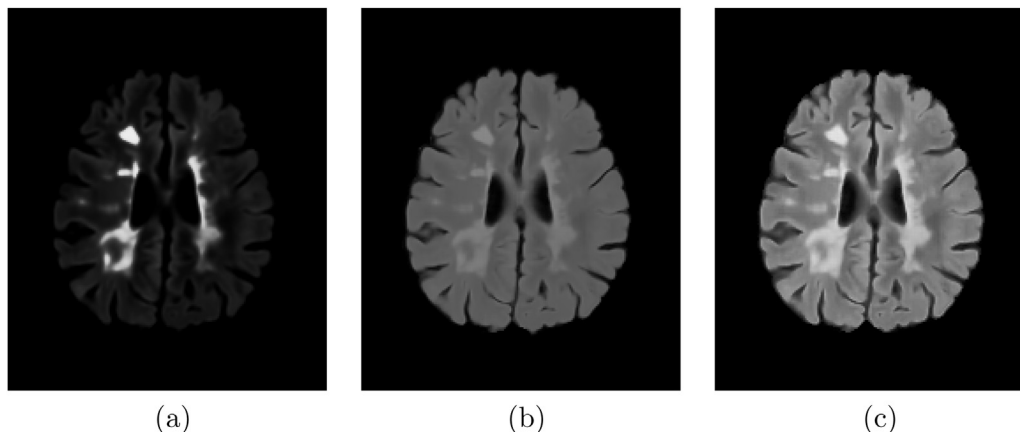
Hyperintensity map (a) compared to the original FLAIR image (b) and the intermediate image (c).
